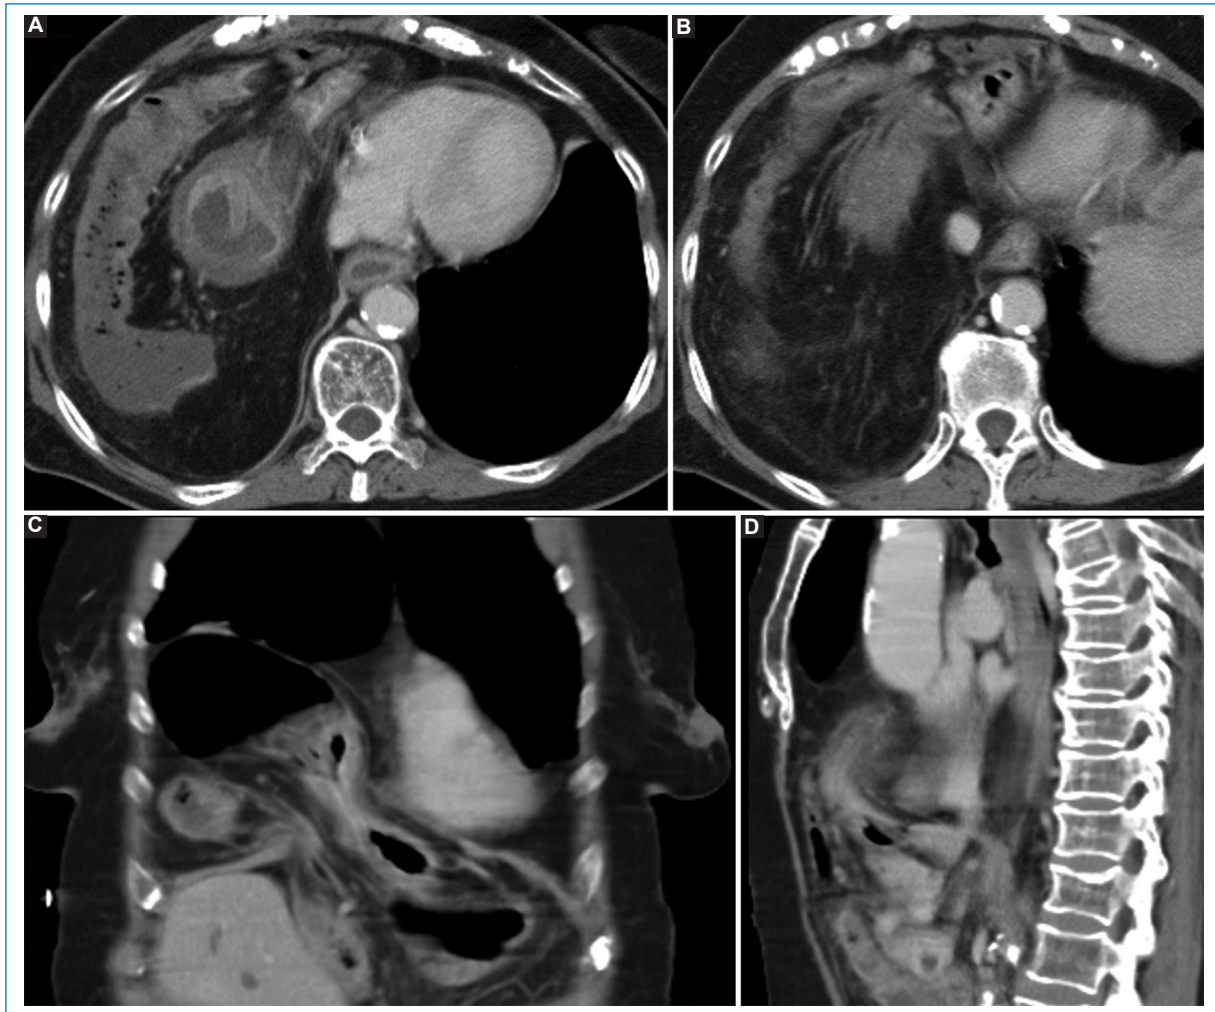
Complicated Morgagni hernia. Selected axial multidetector computed tomography images (A and B) and sagittal (C) and coronal (D) reconstruction.
